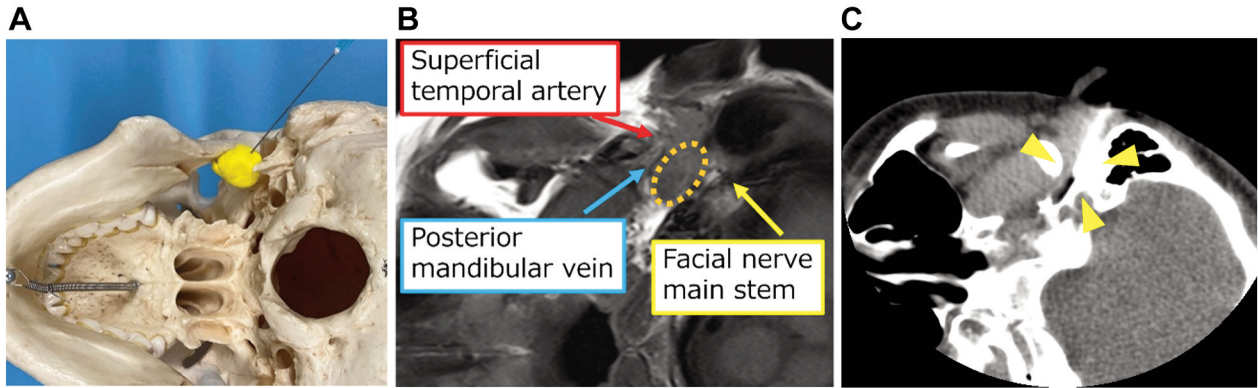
CT-guided fine needle aspiration cytology. (A) The location of the tumor and bone was confirmed using a commercially available skull model. In this model, the position of the tumor was represented with clay, providing a simplified but effective depiction of the tumor's precise anatomical relationship. (B) Contrast-enhanced MRI confirms the location of the superficial temporal artery, posterior mandibular vein, and the main stem of the facial nerve. (C) The puncture route is anterior to the foramen magnum and posterior to the posterior mandibular vein. The mandibular head is used as the meridian, and the puncture is obliquely upward at a level below the mandibular head and below the external auditory canal. The puncture needle is advanced to reach the tumor while obtaining CT images in real-time. CT: Computed tomography. MRI: Magnetic resonance imaging.
